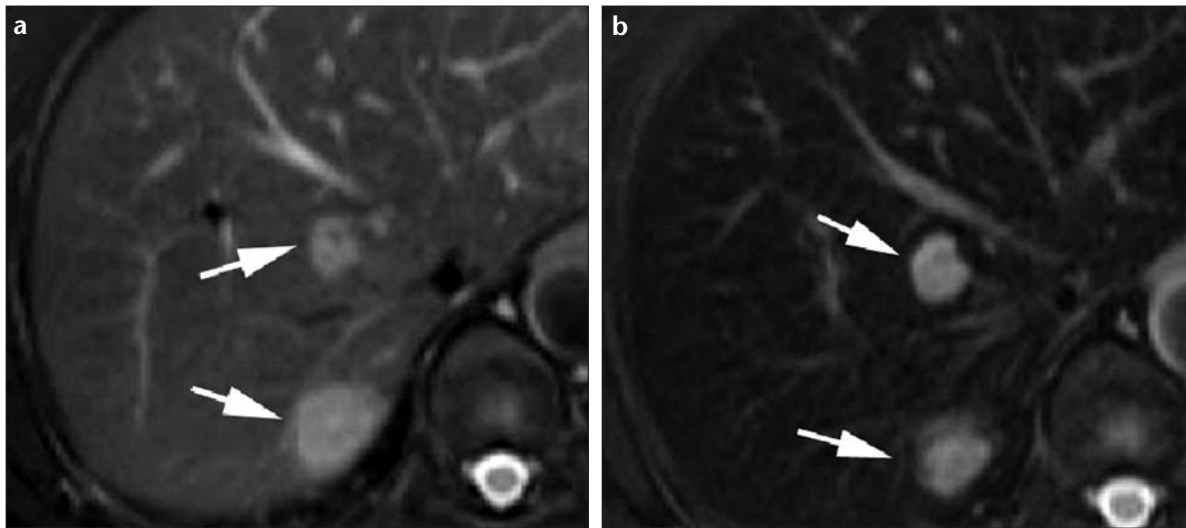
a, b. Metastases of breast cancer. Transverse fat-saturated TSE T2-weighted MR image (a) shows hyperintense metastatic nodules in hepatic segments 7 and 8. T2-weighted MR image after the administration of SPIO (b) reveals no difference in the number of lesions. Because the lesions did not enhance, they became more discernible from the parenchyma.
